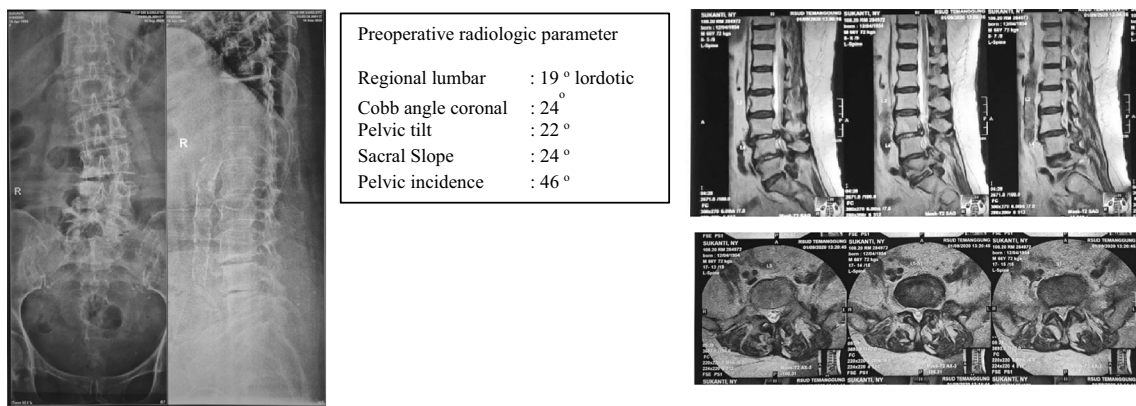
Case 1 initial radiograph presentation.
